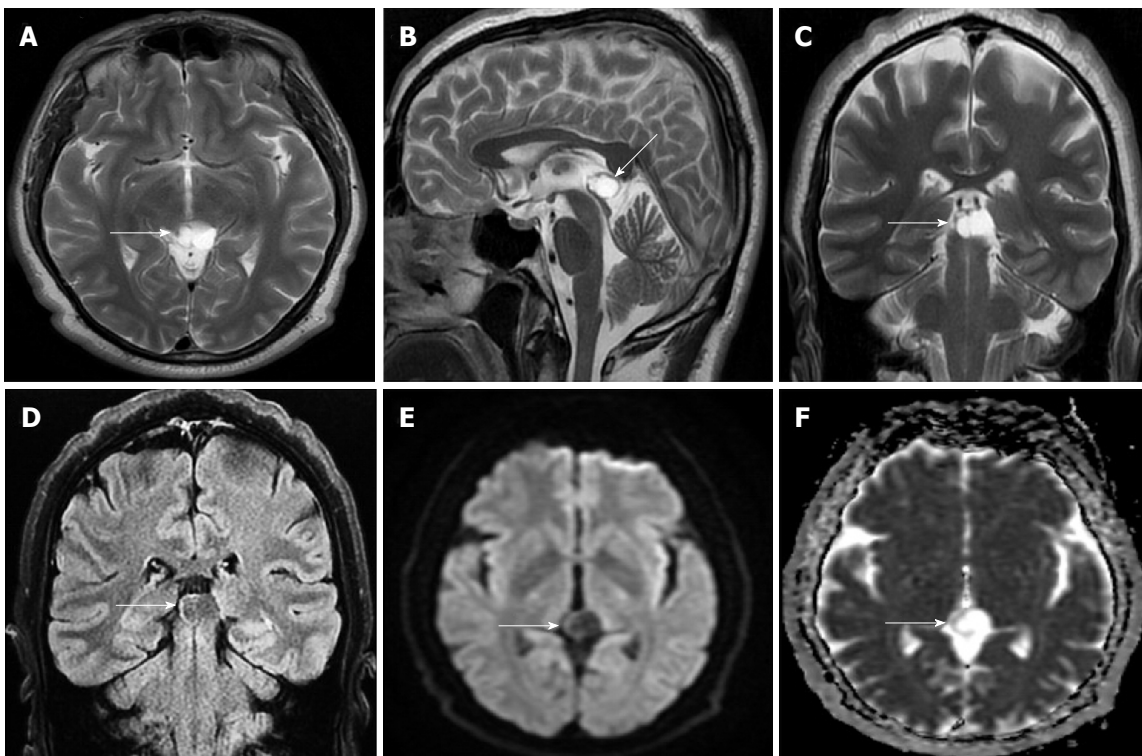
Thirty-three years old female patient with typical pineal cyst (patient No. 42). A: Axial plane T2 weighted magnetic resonance imaging (MRI); B: T1 weighted MRI; C: Sagittal plane T2 weighted MRI; D: Coronal plane FLAIR MRI. Typical pineal cysts are shown in the pineal region with unilocular homogeneous internal structure (white arrows, A, B, C and D); Isointense cyst with CSF (A, B and C); The slightly hyperintense pineal cyst compared to CSF is shown on FLAIR sequence (D). CSF: Cerebrospinal fluid; FLAIR: Fluid-attenuated inversion recovery.
